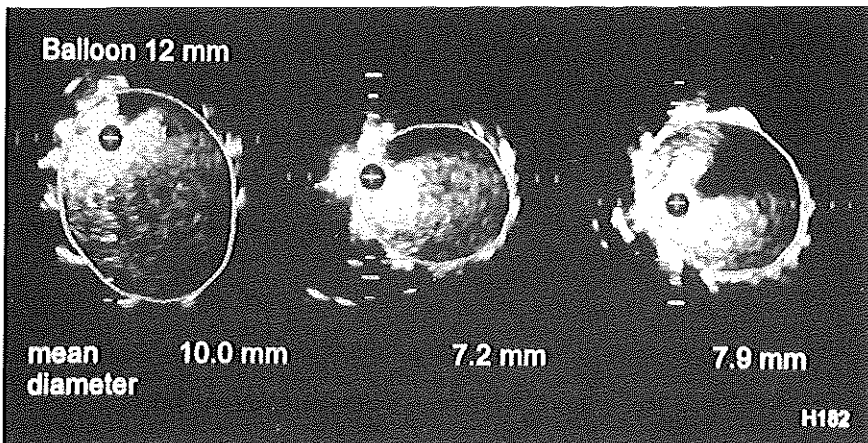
Intravascular ultrasound cross-sections of the iliac artery after stent-graft placement for an aneurysm using a 12 mm balloon. Diameters of the proximal stent edge (A), intra-stent (B) and distal stent edge (C) are smaller than the balloon diameter used. + = catheter; calibration 1 mm.
